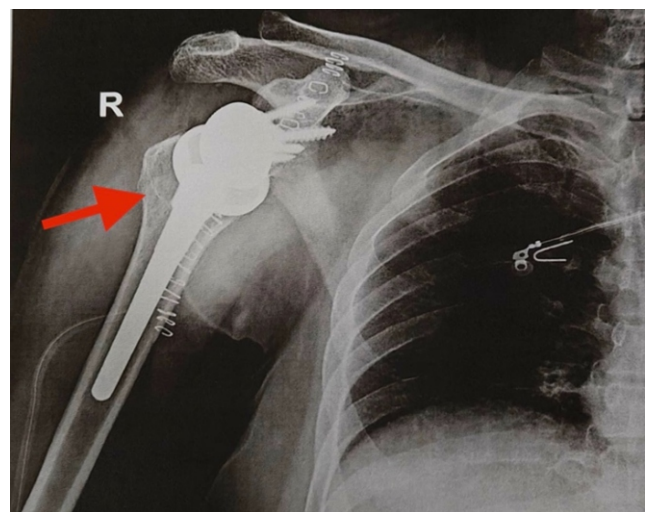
Post-operative radiograph showing metaphyseal bone grafting (red arrow) at the metaphyseal bone-implant interface.
